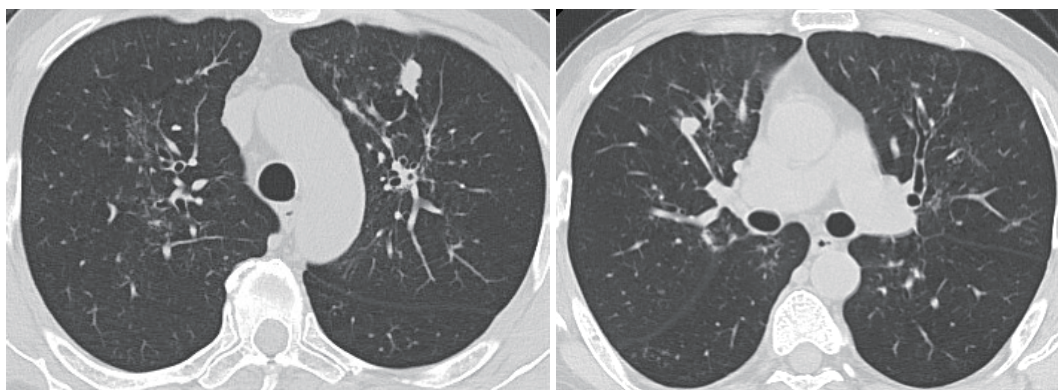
Chest CT performed one month after the initial visit but after admission showed that most of the nodule shadows had either diminished or completely disappeared, but the relatively large nodules remained.
